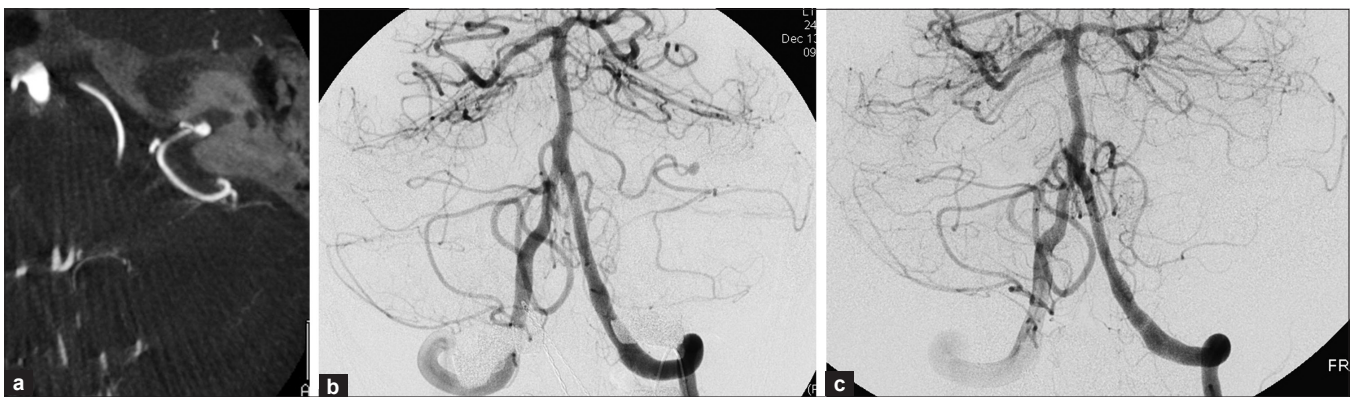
a) A CT angiogram (axial view) depicts a distal left AICA aneurysm projecting into the left auditory canal. b) Selective vertebral angiogram (frontal view) showing a 2.5-mm aneurysm arising distal to the meatal loop of the left AICA. c) Postoperative angiogram demonstrating complete obliteration of the aneurysm with absent filling of the AICA. There is also an area of hypoperfusion in the inferior left cerebellar hemisphere
